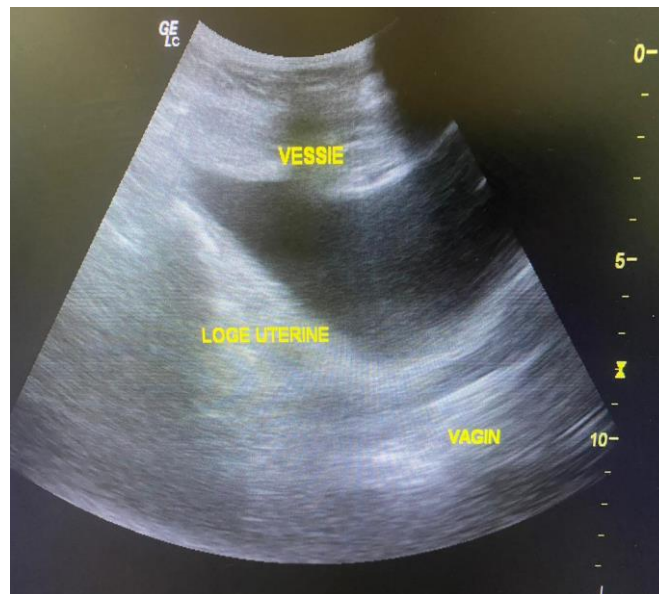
Uterus not seen in pelvic position on suprapubic ultrasonography
